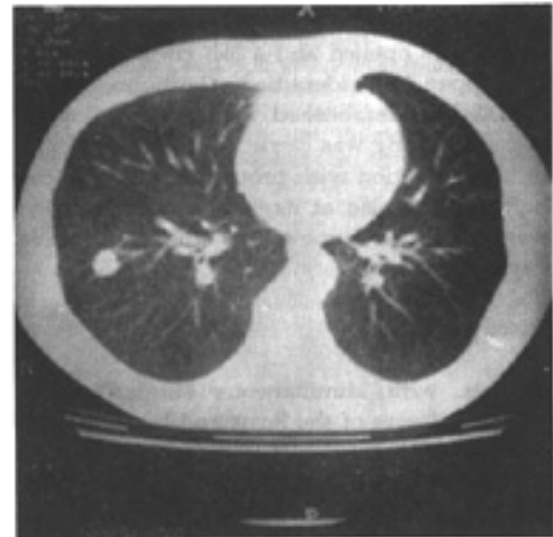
CT scan of the chest which shows a well-defined 1.5 cm nodule in the right lower lobe (Case 2).
